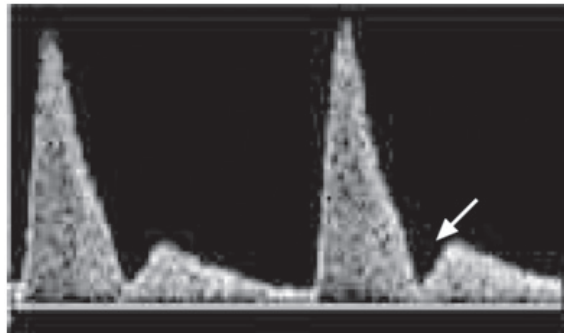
Doppler study in normal pregnancy
